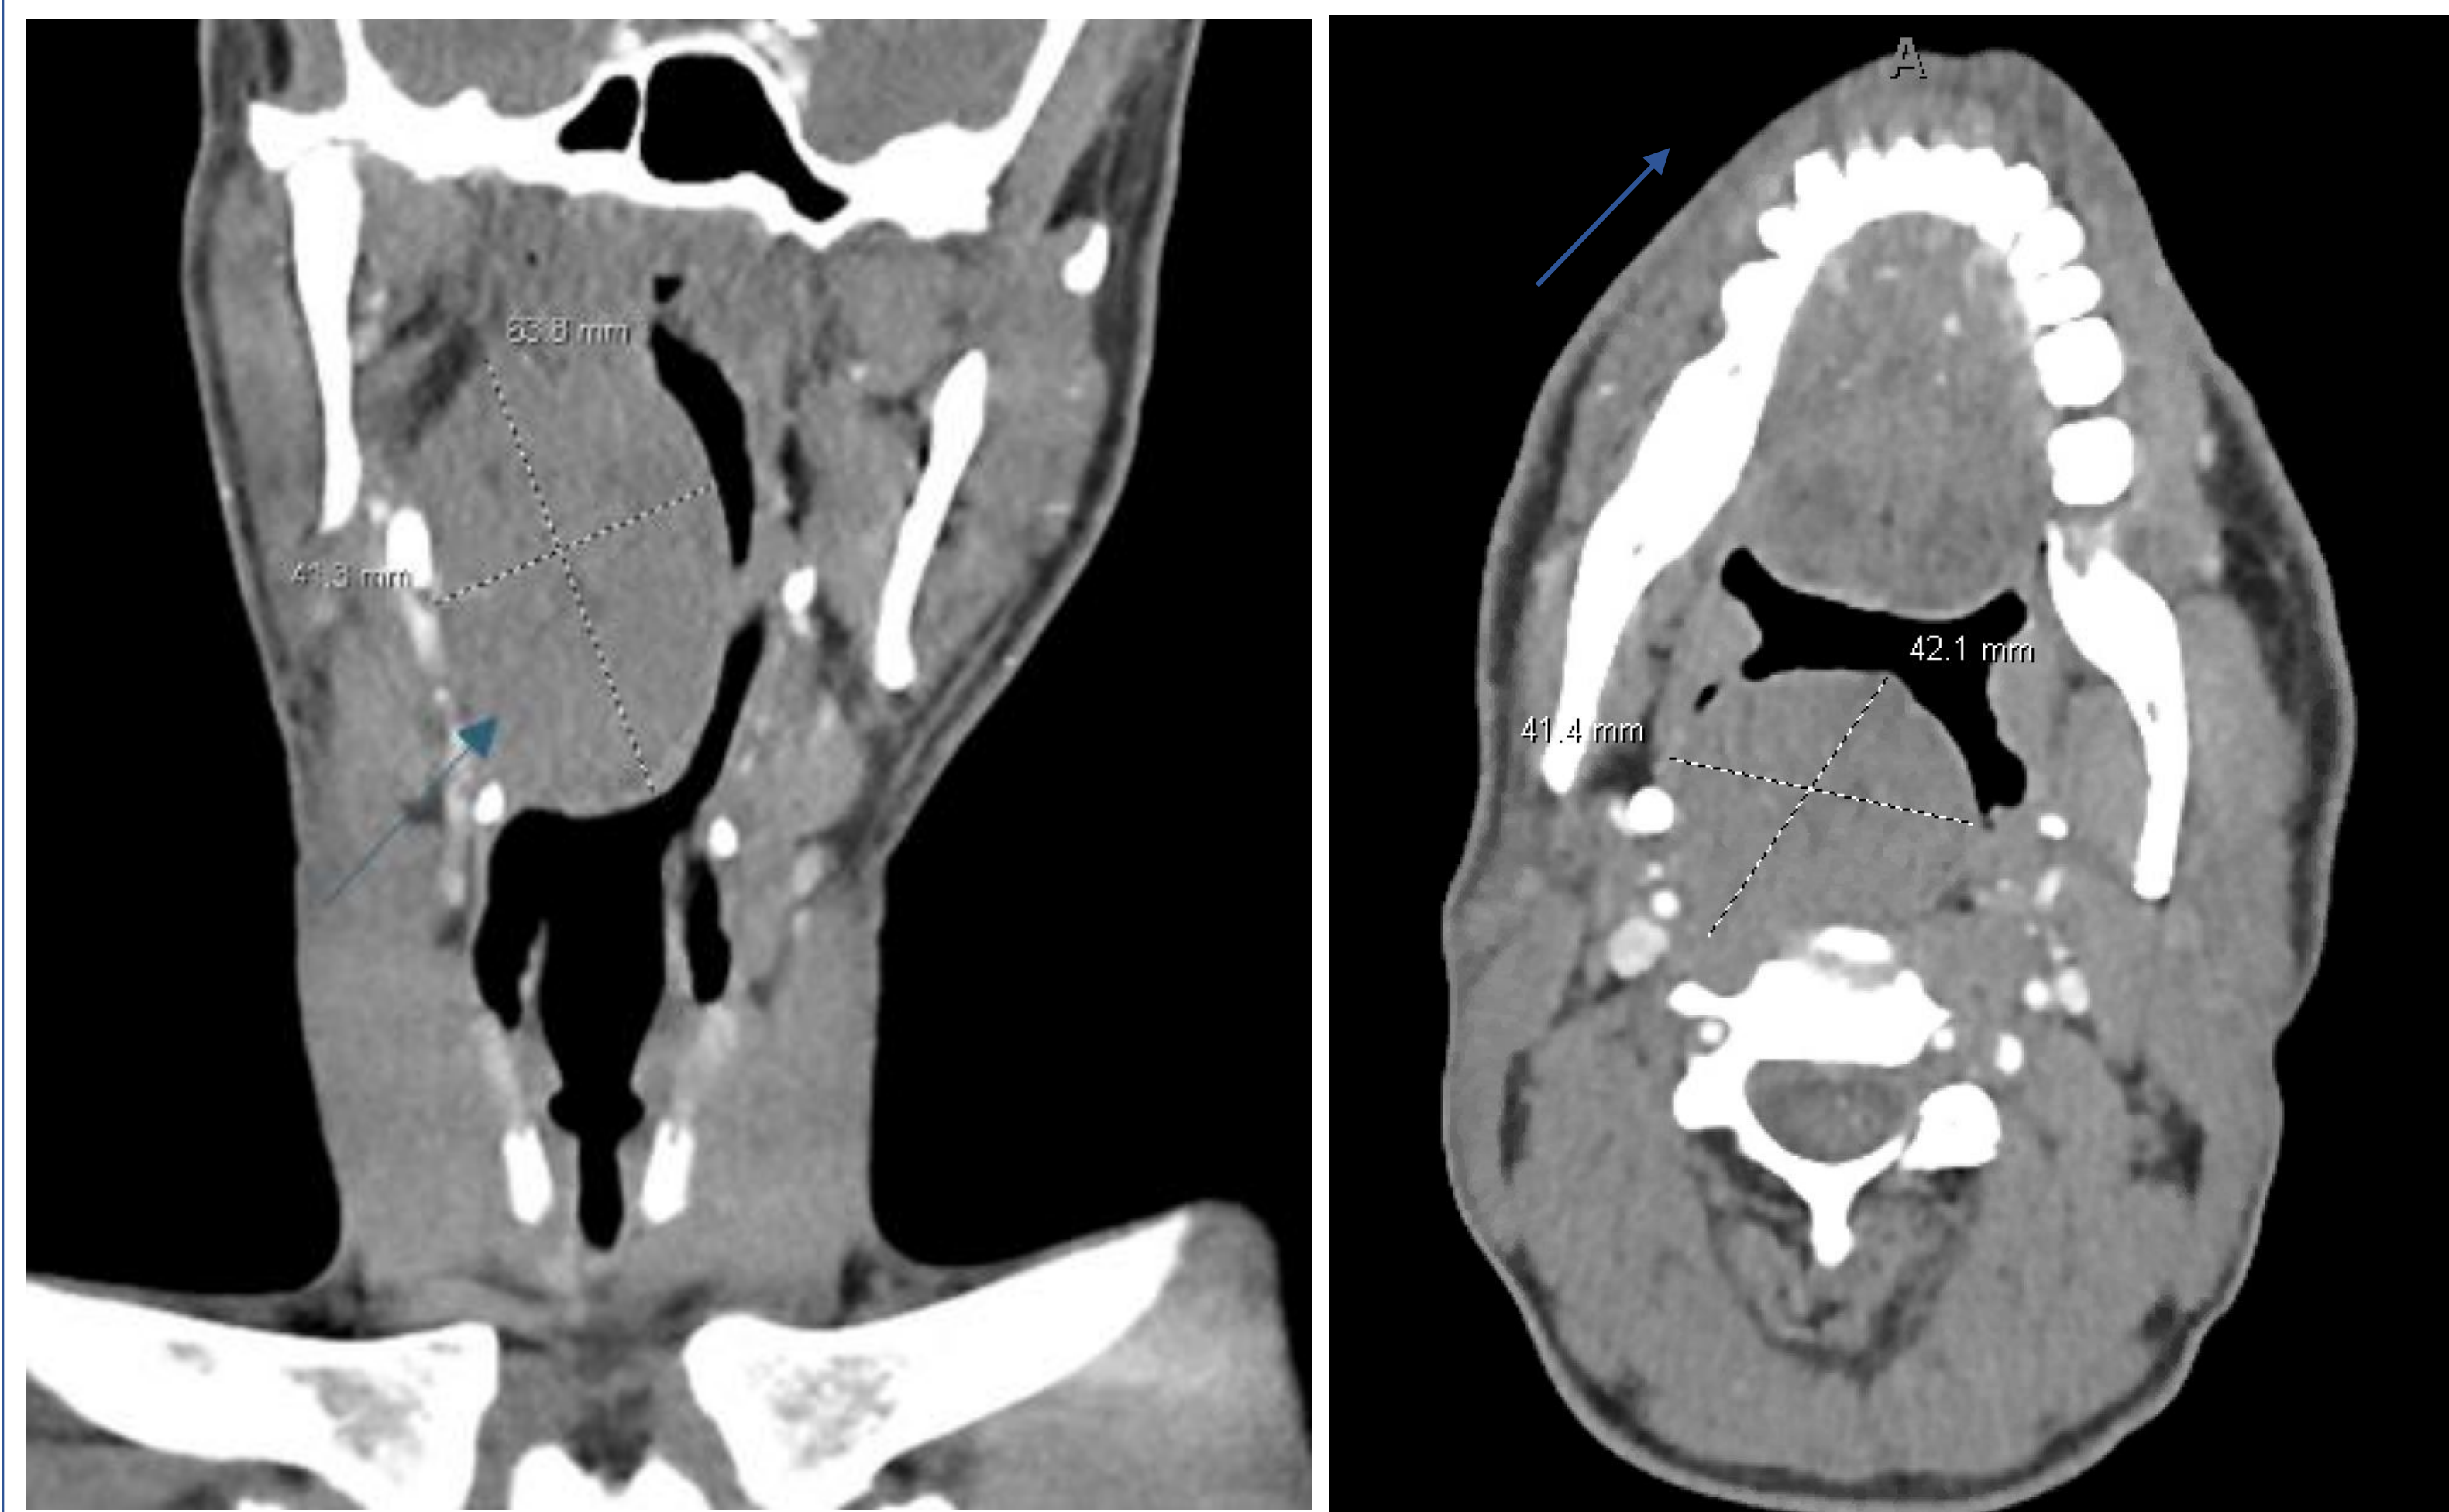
(coronal) and Figure 2 (axial): Contrast-enhanced CT demonstrating a large posterior pharyngeal wall GCT (blue arrow) prior to TORS, mass measures approximately 6.5 × 4.0 × 4.2 cm
